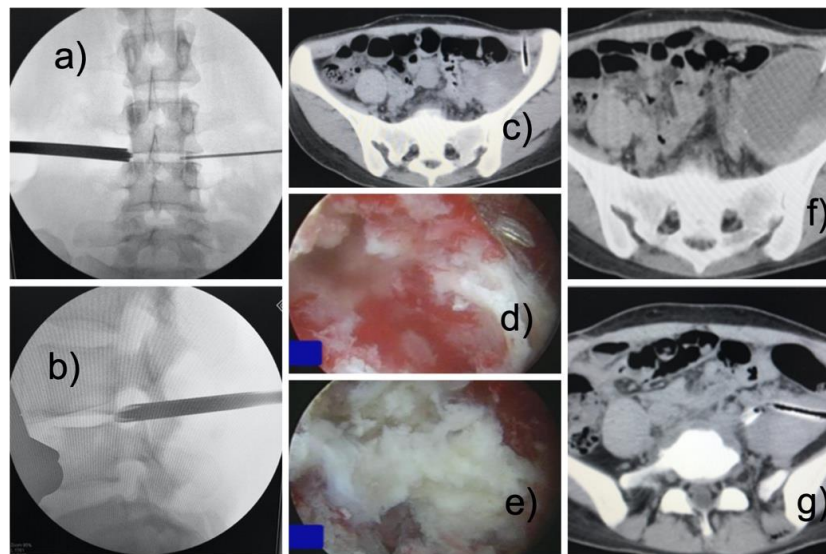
Intraoperative puncture location (a, b), the side with severe symptoms are cleared under endoscopy. A double-lumen perfusion irrigation tube is placed (c), and an epidural tube is placed on the opposite side. Endoscopy shows the necrotic tissue in the intervertebral space and the situation after cleaning (d, e). Selecting the largest part of the iliac fossa abscess, a CT-guided puncture to the abscess anteriorly was performed by placing an indwelling a double-cavity perfusion irrigation tube for continuous irrigation and drainage.
